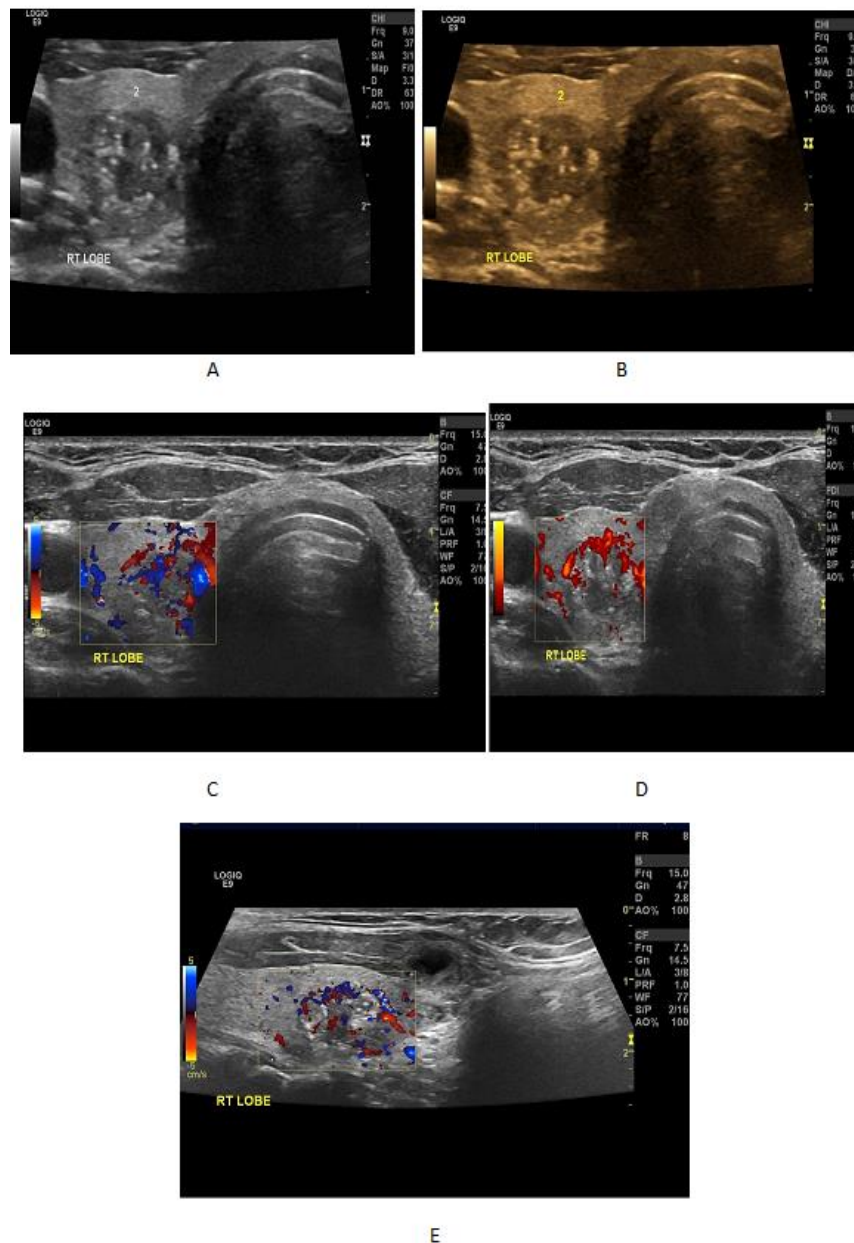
A, B is gray scale ultrasound shows nodule about 1.5 cm in maximum diameter, with punctate echogenic foci, solid, hypoechoic; C, D and E shows central and peripheral marked vascularity, on FNA is malignant.
